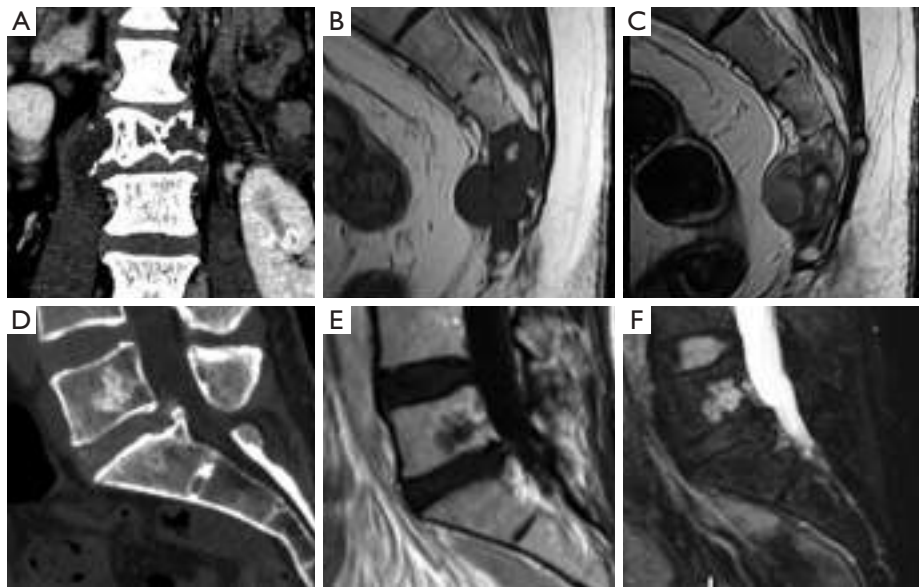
Notochordal tumors. (A) Coronal reformatted CT of a lumbar chordoma. (B) Sagittal T1 without and with contrast (C) of a sacral chordoma. Sagittal reformatted CT (D), T1 (E), and STIR images (F) of a benign notochordal tumor. CT, computed tomography; STIR, short tau inversion recovery.
